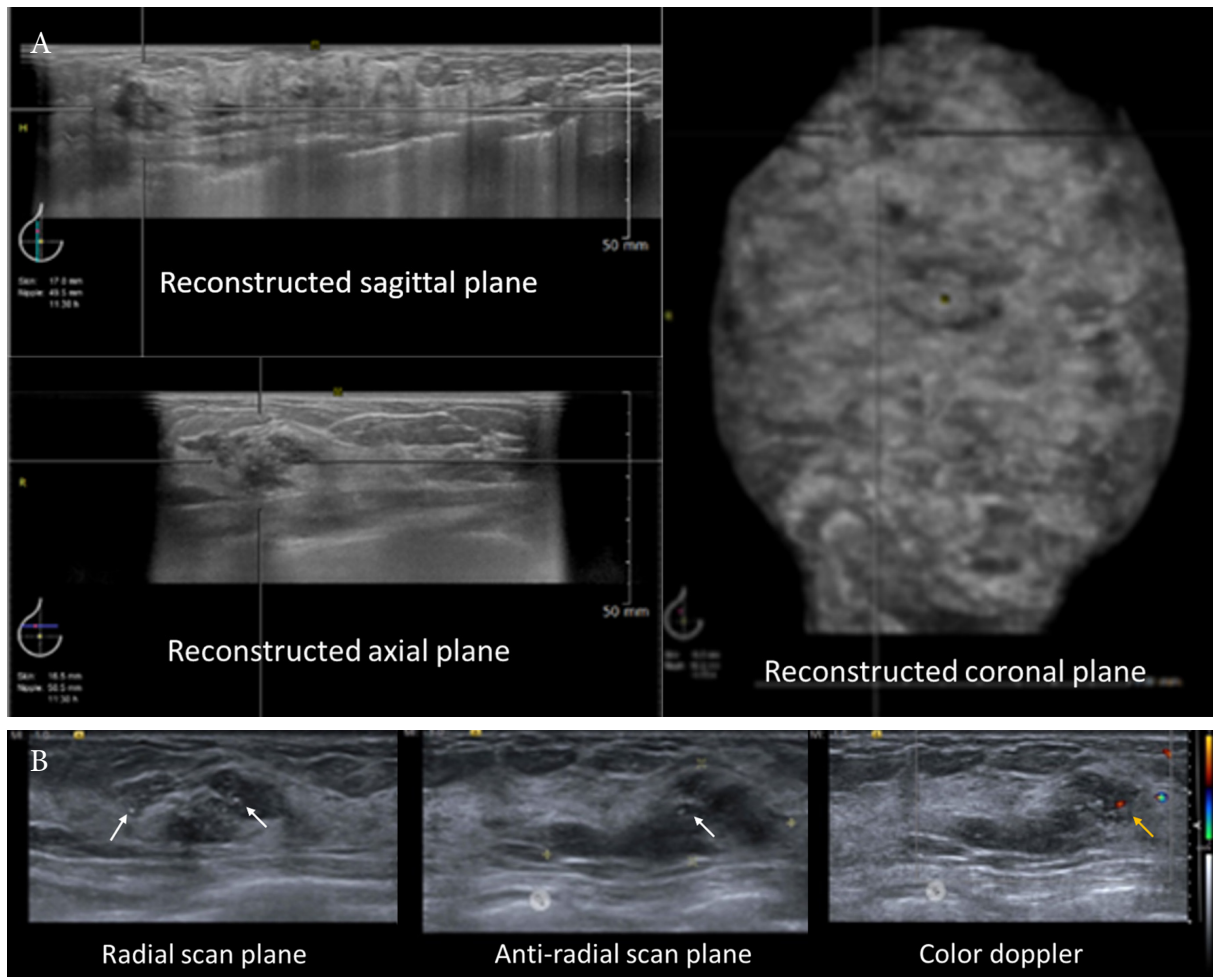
Ultrasound findings in ABUS (A) and HHUS (B) showed an irregular, indistinct, hypoechoic mass with parallel orientation, the combined pattern of posterior features and internal calcification at 11-12 o'clock of the right breast (White arrow). Internal vascularity was seen at the medial portion of the mass (Yellow arrow). (BI-RADS IVc) The pathologic result was high-grade ductal carcinoma in situ (DCIS).*
